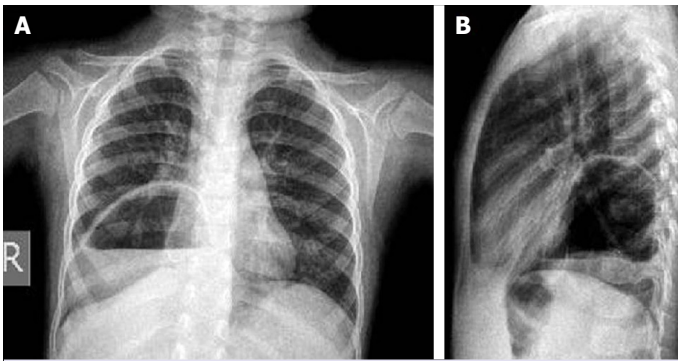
(A) A-P chest X-ray of patient 4 showing a slightly median air–fluid level on the right hemithorax. Gastric air is absent in its usual location. (B) Lateral chest X-ray of the same patient showing that the air–fluid level is placed posteriorly. This patient had type IV HH.
